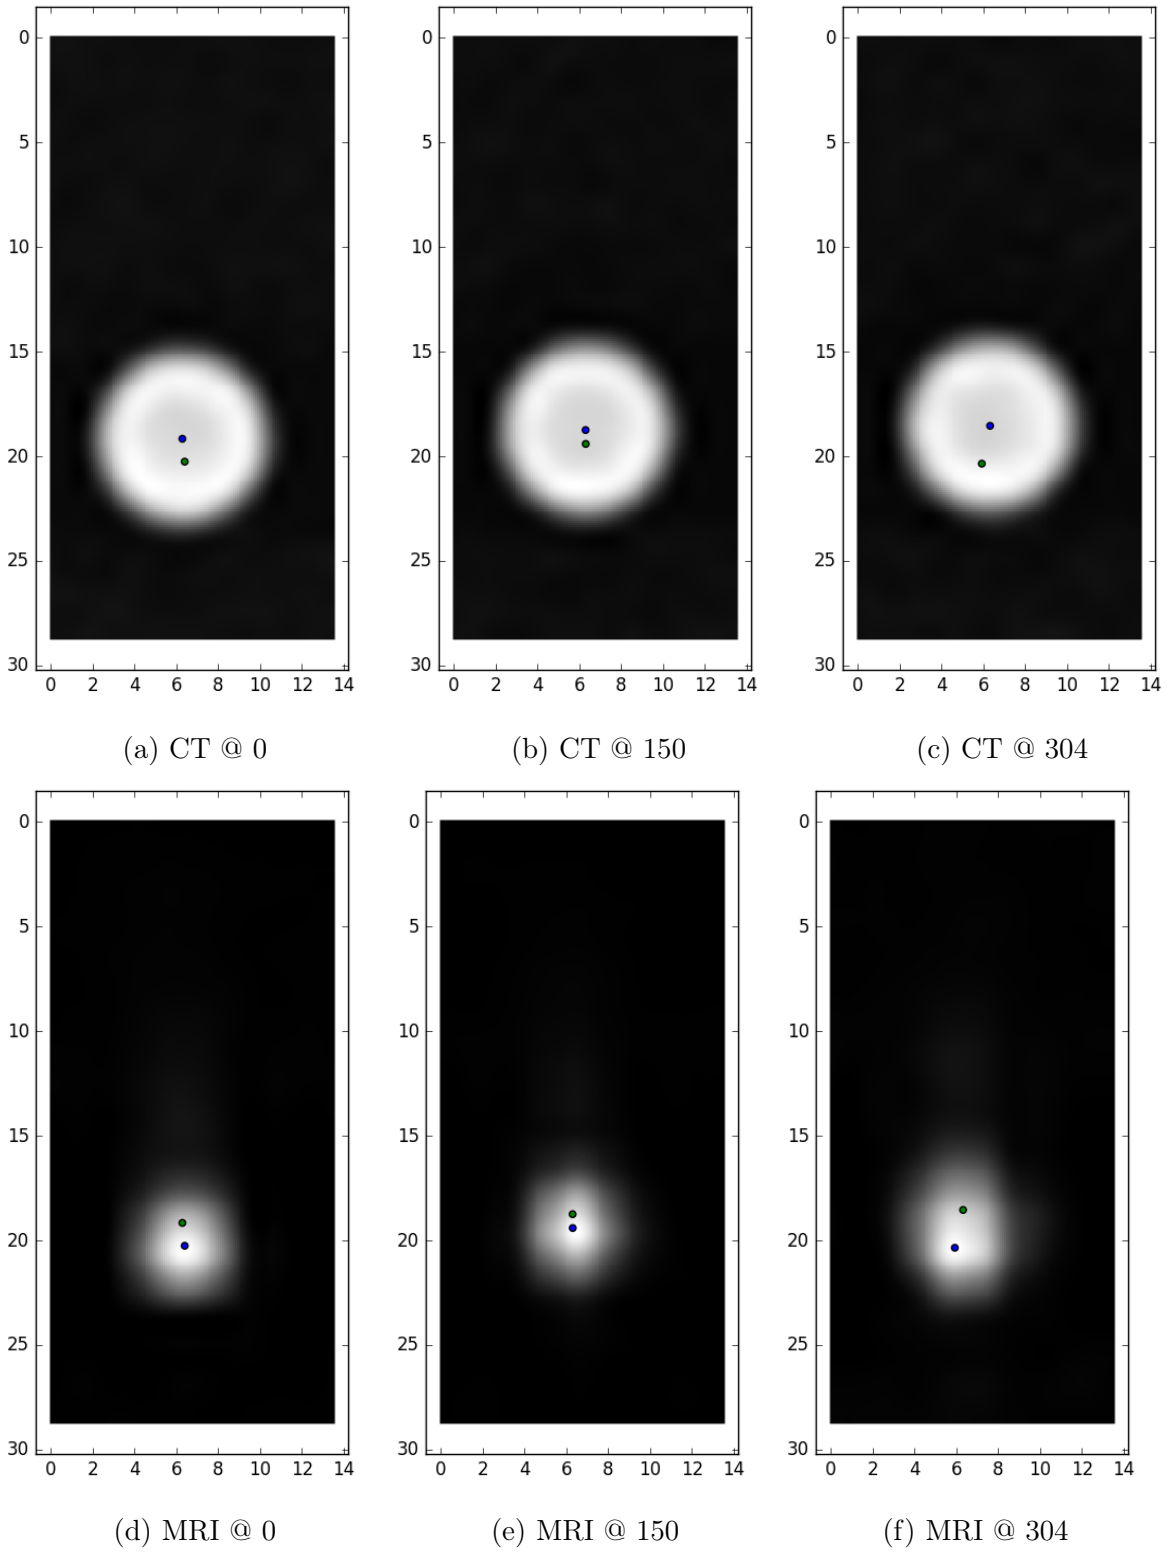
MRI x100; blue dot centroid MRI, green dot centroid CT (same scale);
